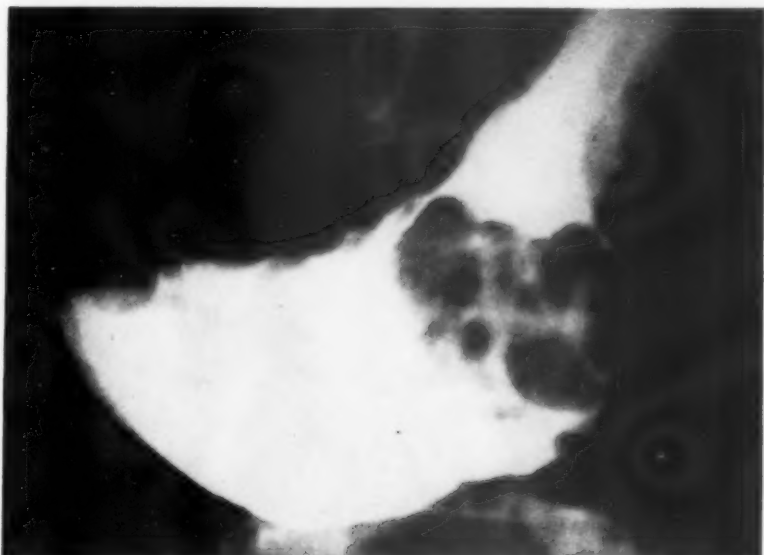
Roentgenogram showing polypoid filling defect outlined with barium.
